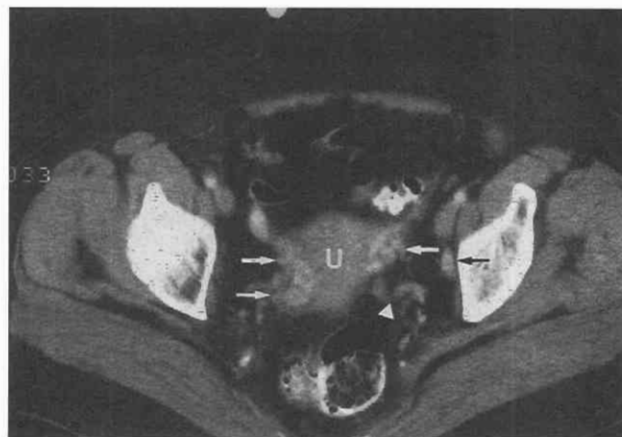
Normal anatomy. CT scan through the uterus (U) shows a tortuous left uterine artery and prominent vascular plexus (white arrows) running within the broad ligament. In the left obturator fossa a contrast-enhanced structure (black arrow) probably represents a pelvic varix.
